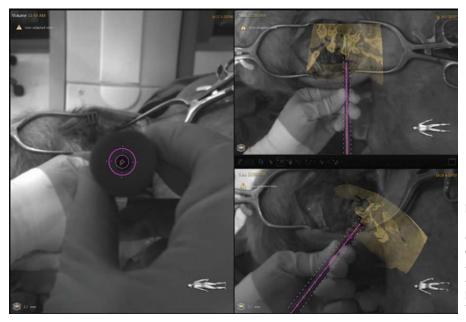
Augmented reality with optical camera based navigation and tracking, viewport on the left correspond to the view along the axis of the device, top right and bottom right correspond to oblique view from two other cameras for fine alignment of the device along the virtual path and screw augmented with a CBCT slice. In this particular example, the operator desired to have two alignment views only.
